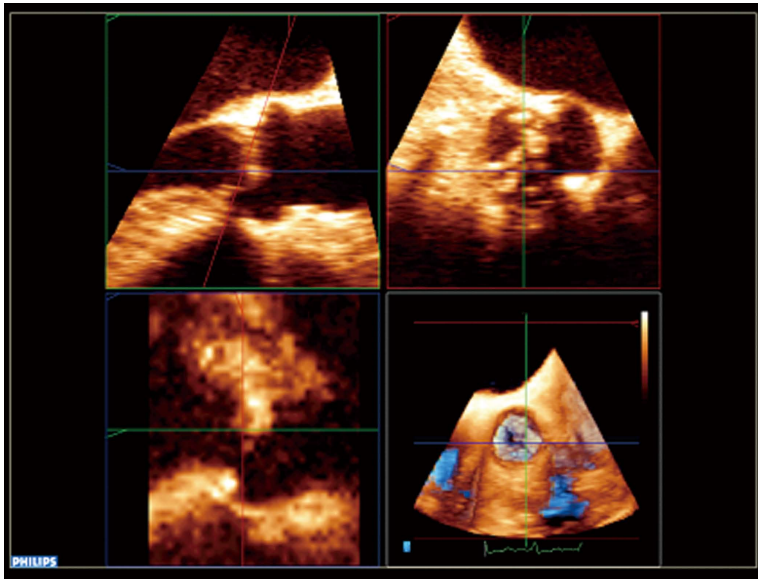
Transesophageal echocardiography 3D with multiplanar projection showing the measurements at annulus level.
